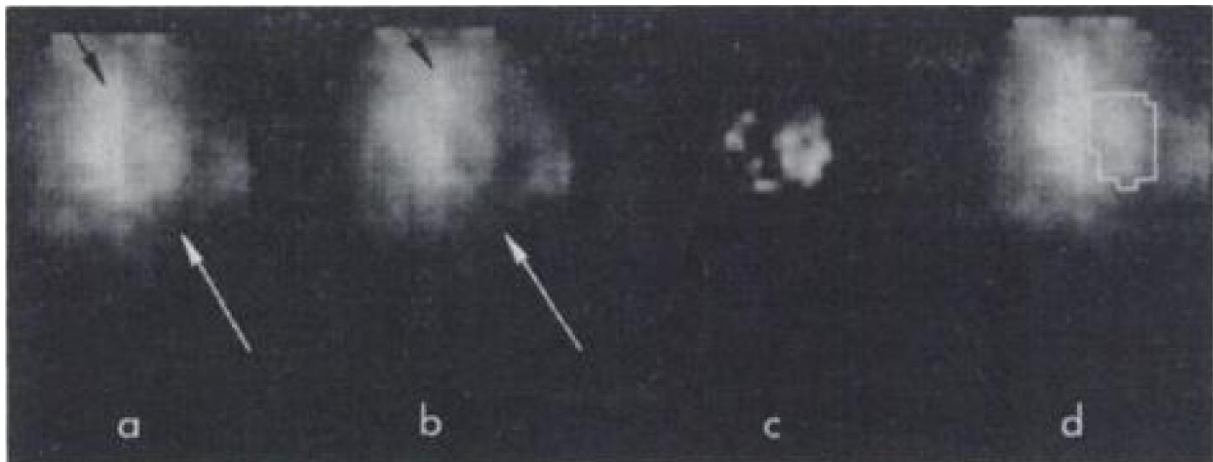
One of the first cardiac gated acquisitions, showing blood-pool scintigraphic images of ^{99}Tc -human serum albumin (^{99}Tc -HSA) in end-diastole (a), end-systole (b), end-diastole minus end-systole (c) and outlined region of the ventricular blood-pool (d). The left-ventricular ejection fraction was derived from the images by comparing the measured counts in diastolic and systolic images. Reprinted by permission of the Society of Nuclear Medicine from [270].
